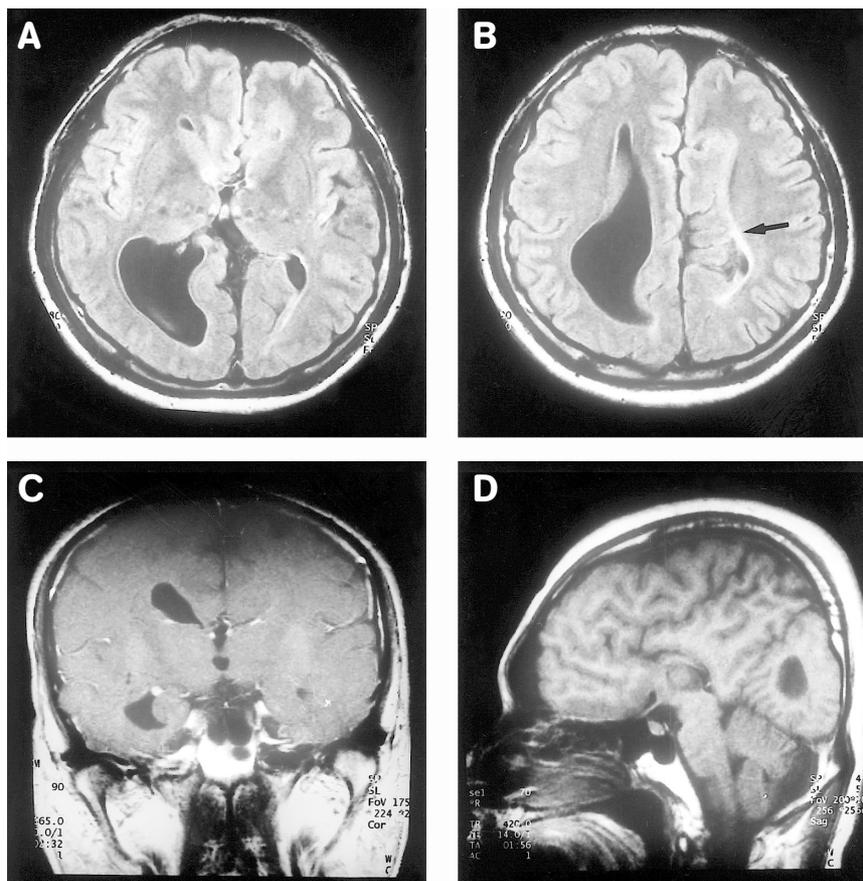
MRI of the brain in 2002 revealed total absence of the corpus callosum; asymmetric enlargement of right lateral ventricle, especially occipital horn (colpocephaly), and right temporal horn, indicating maldevelopment of right medial temporal lobe; maldevelopment of left lateral ventricle with gray matter abutting left occipital horn; and ectopic gray matter in the regions where frontal horn and lateral ventricle should be located (arrow).
